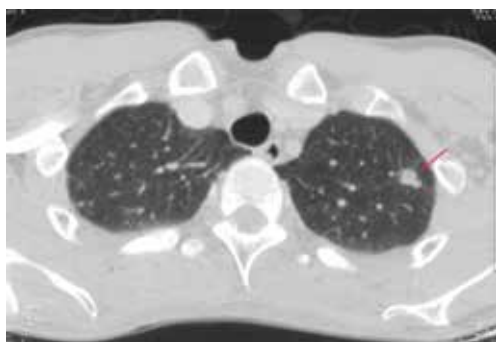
CT shows a case of a small hamartoma (arrow) appearing as a non-calcification solid nodule with lobulated margin, mimics a malignant nodule.
